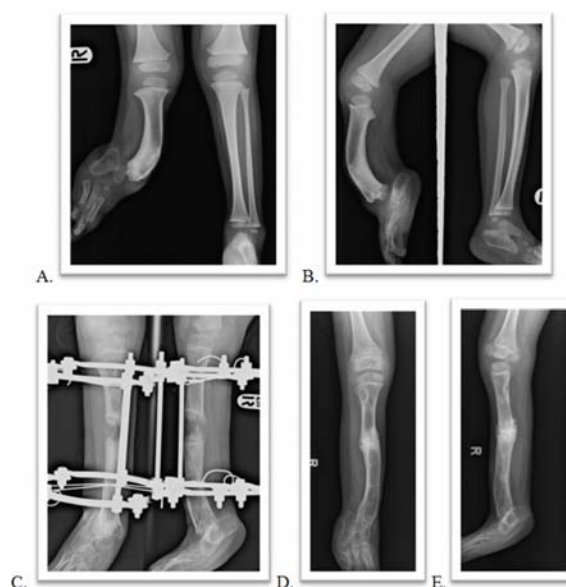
Fibular hemimelia Type II is shown above A, B) Preoperative standing radiograph of a three-year old boy presenting with right fibular hemimelia Type II with a limb-length discrepancy of 6 cm at initial and absent 2 toes C) Radiograph of lengthening using the Ilizarov method D, E) Postoperative radiograph at follow-up after bone lengthening, showing mild equinus foot.
